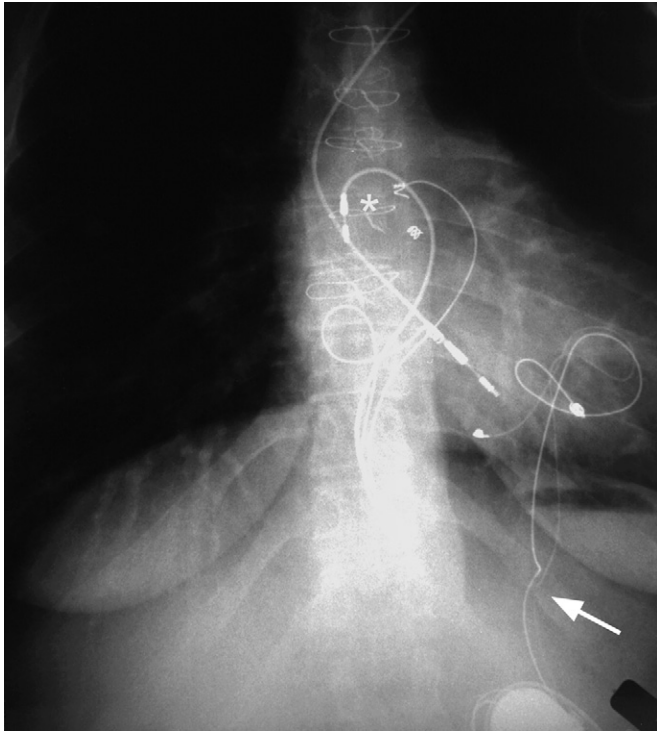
Chest x-ray film of a patient with many abandoned pacing leads. There is a bipolar transvenous lead with the tip in the right ventricle. Another bipolar transvenous lead has been used as an epicardial atrial lead (*asterisk*). There are two screw-in epicardial leads, one atrial and one ventricular. The atrial lead has a fractured electrode. There are two other types of epicardial leads more toward the apex, one of which is fractured (*arrow*), and the other of which is kinked. Only the kinked lead is functional. (From Sliz NB Jr, Johns JA: *Cardiac pacing in infants and children*, *Cardiol Rev* 8:223-239, 2000.)
